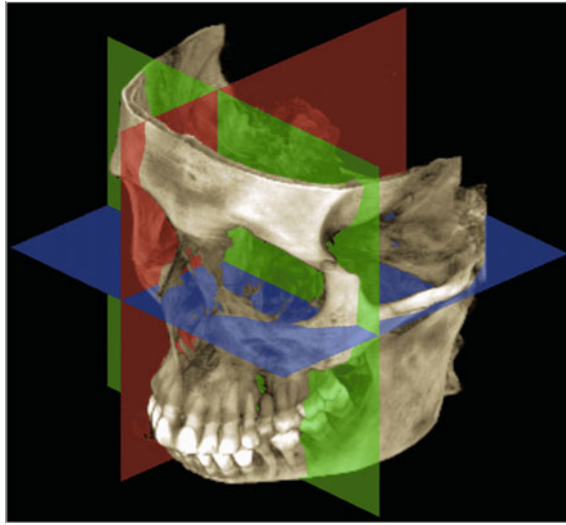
Multiplanar visualization of CBCT images; *green* coronal; *blue* axial; *red* sagittal
